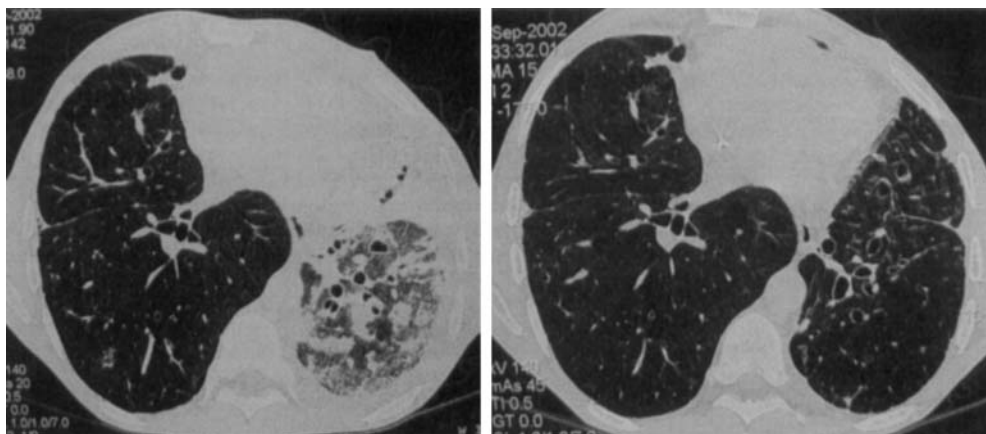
(Left) HRCT of the chest after first-line anti-fungal treatment, (right) comparable HRCT cut following caspofungin treatment and hospital discharge
